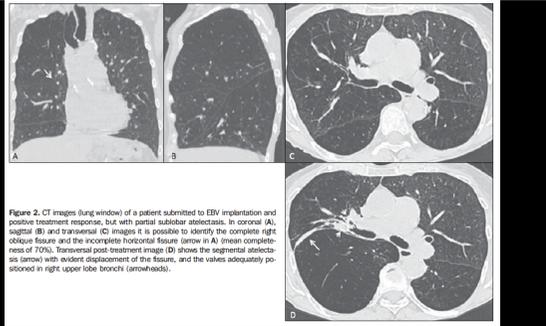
CT images (lung window) of a patient submitted to EBV implantation and positive treatment response, but with partial sublobar atelectasis. In coronal (A), sagittal (B) and transverse (C) images it is possible to identify the complete right oblique fissure and the incomplete horizontal fissure (arrow in A) (mean completeness of 70%). Transverse post-treatment image (D) shows the segmental atelectasis (arrow) with evident displacement of the fissure, and the valves adequately positioned in right upper lobe bronchi (arrowheads).
